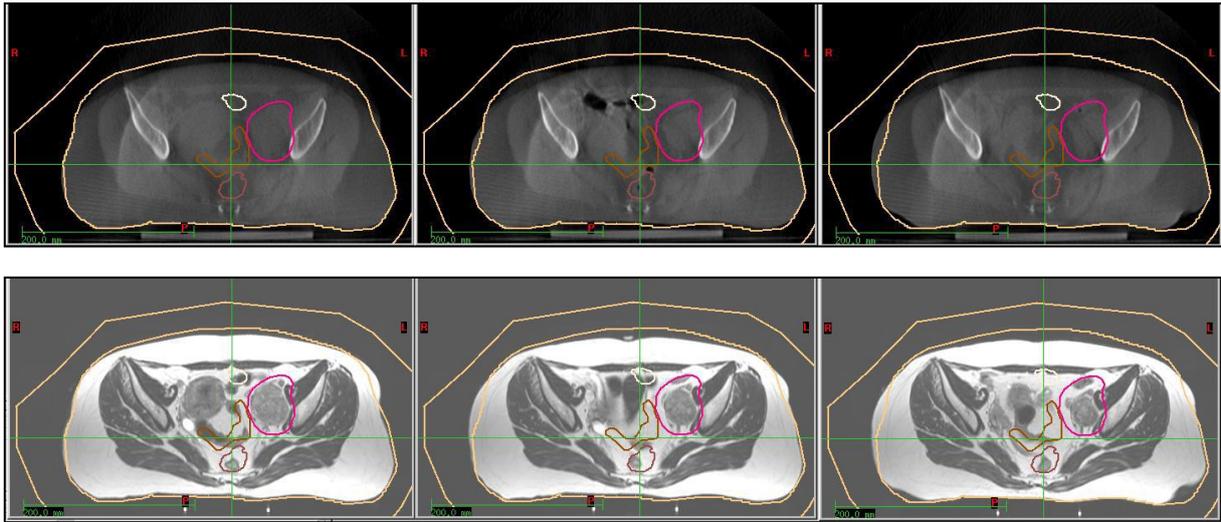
CBCT (top) and MR T2 (bottom) images of treatment sessions 6, 11 and 16 (from left to right), where the contours are propagated from the treatment planning CT.
